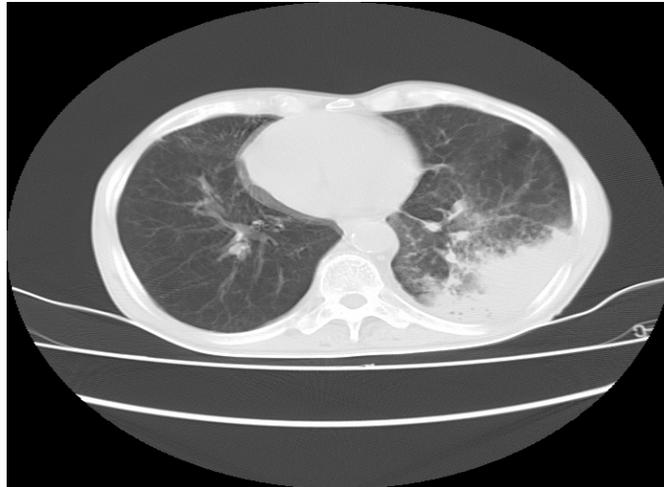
CT-Chest - Consolidation
